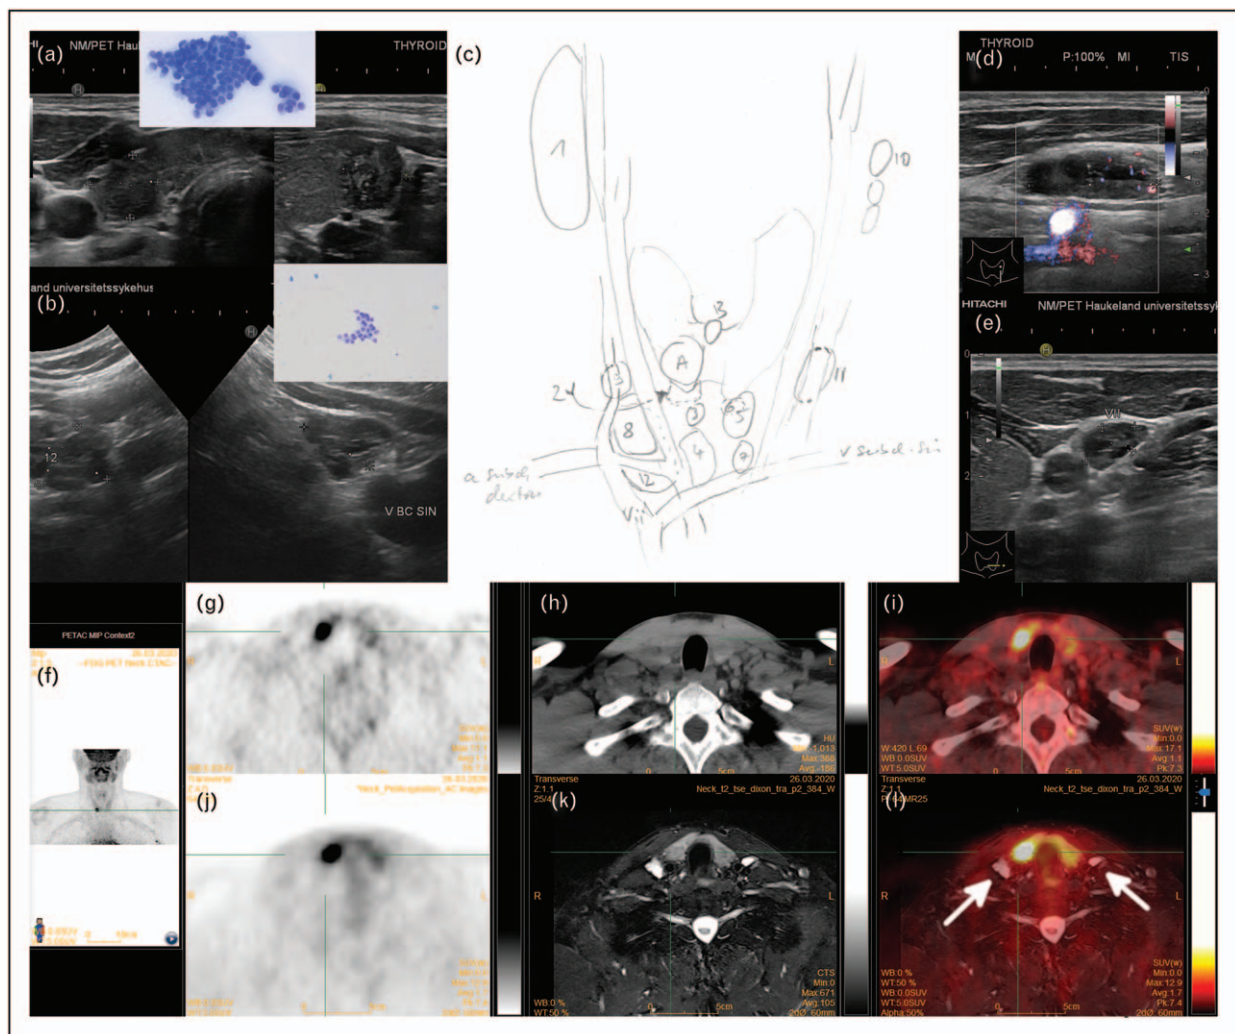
A 34-year-old man presenting with a right lateral neck mass. Contrast-enhanced CT requested by the initially consulted otorhinolaryngologist had revealed multiple lesions in the right lateral neck. Ultrasound at our centre showed a 10 mm hypoechoic nodule 'A' (a) in the right thyroid lobe and multiple cystic LN on both sides of the neck (b–e). FNB of thyroid nodule 'A' (inset panel) and right cervical LN #8 (inset panel b) established the diagnosis of PTC. Thyroglobulin in the aspirate from LN #8 was more than 2000 ng/l. [^{18}F]FDG-PET/CT (f–i) revealed uptake only in thyroid nodule 'A' but not in the cystic LN. CT without intravenous contrast (h) did not add any relevant diagnostic information. On PET/MR (panels j–l), all cystic LN (arrows in panel l) were hyperintense on T2-weighted series. This helped us clarify the difficult anatomic relationships around LN #12 (b). Total thyroidectomy with systematic LN dissection confirmed a 12 mm PTC in the right thyroid lobe and LN metastases in 20/29 LN in the central, 4/12 in the right and 2/10 left neck, respectively. FNB, fine needle biopsy; LN, lymph node.
